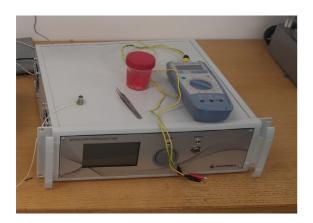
Ultrasound generator VT-400.
